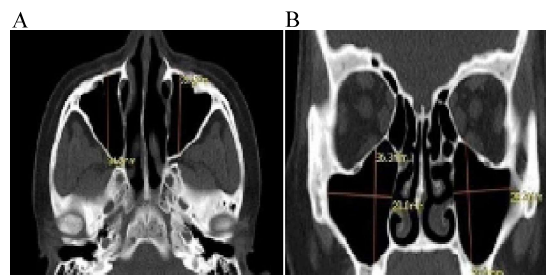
Axial CT scan showing AP measurement of right and left maxillary sinus (A), coronal CT scan showing SI and ML measurements of right and left maxillary sinuses (B)
